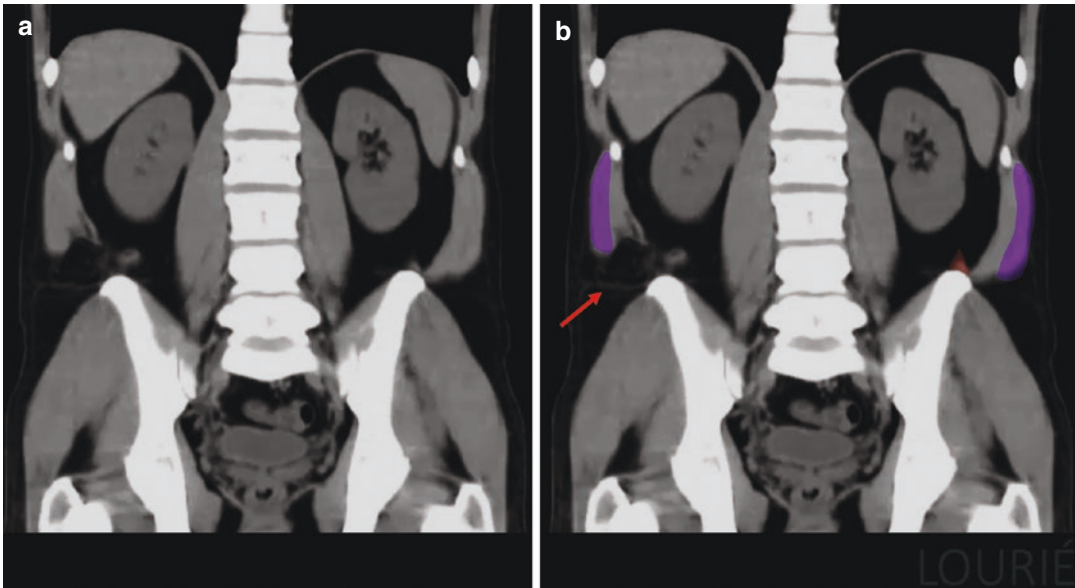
Right-sided Petit's hernia. (a) Coronal CT abdomen/pelvis cut, same patient as (Fig. 20.4) (b) Same image, colored. Note that the herniation (*red arrow*)
